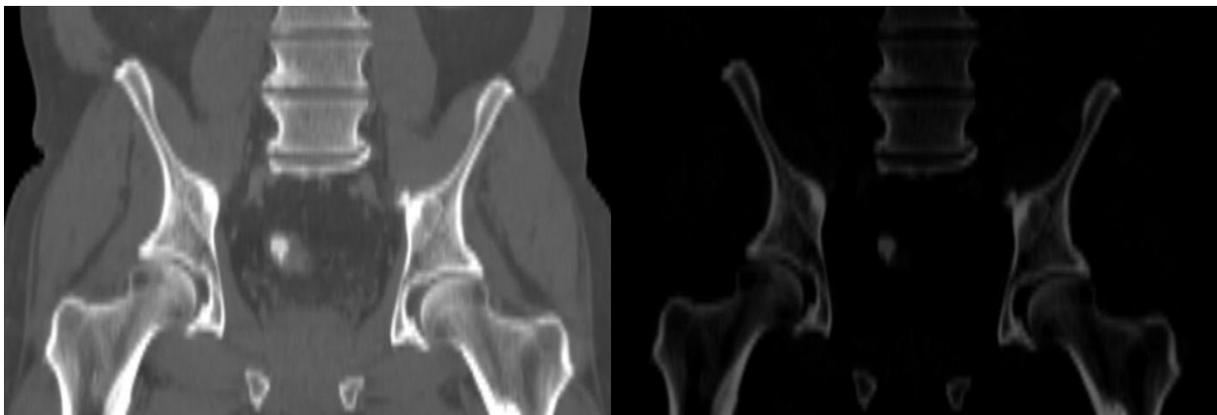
(left) CT slice displayed where WL = 250 and WW = 1450. (right) CT slice displayed where WL = 1800 and WW = 3500.
